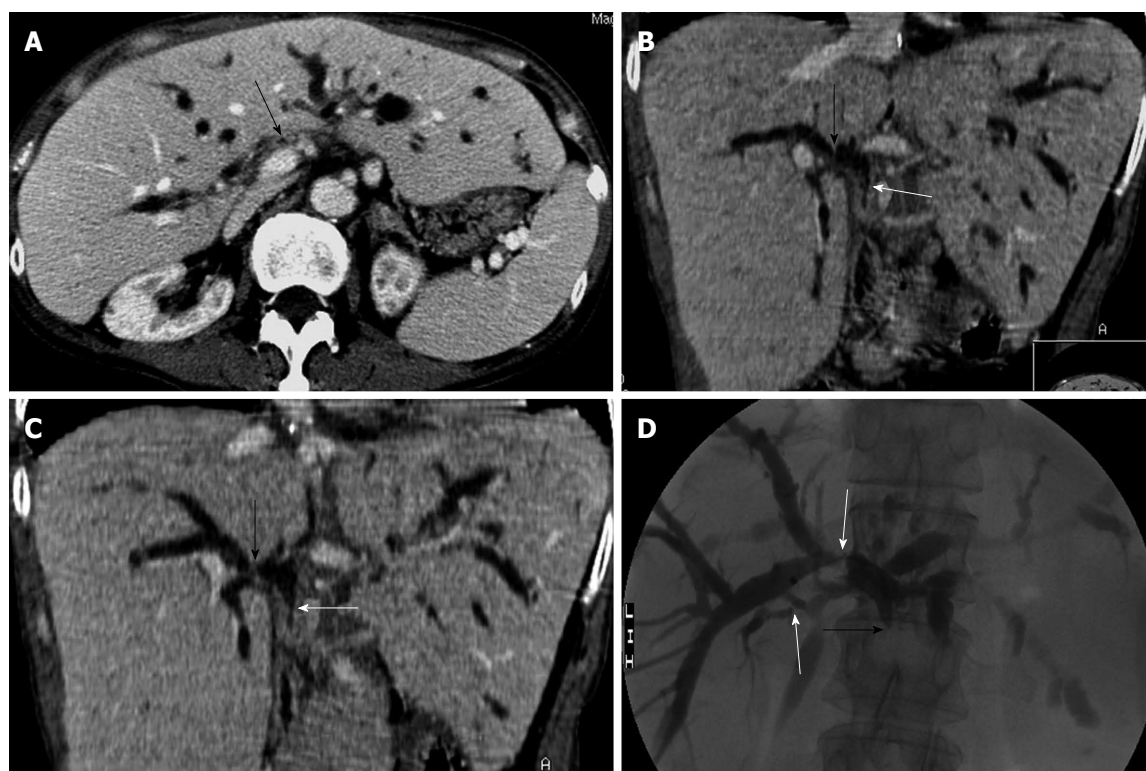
A 66-year-old woman with obstructive jaundice due to nonanastomotic biliary strictures 11 mo after orthotopic liver transplantation. A: Transverse computed tomography (CT) image on the portal venous phase shows marked stenosis of the hepatic hilar bile duct (arrow) and dilation of the intrahepatic bile ducts; B,C: CT oblique reformat image shows biliary stenosis at the hepatic bifurcation (black arrow) and the donor common duct (white arrow); D: Percutaneous transhepatic cholangiography demonstrates the stenosis of intrahepatic bile duct and hepatic bifurcation (white arrow), and complete occlusion of the donor common duct (black arrow).
